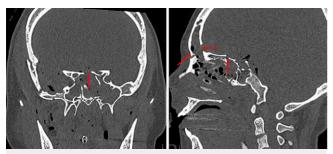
Case 4. Left: Preoperative coronal CT with multiple fractures (*red arrow*). Right: Preoperative sagittal CT with frontal sinus and planum sphenoidale fractures (*red arrows*).
